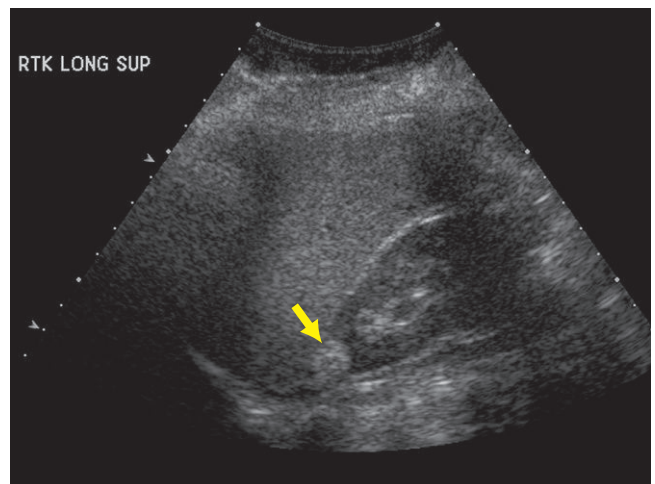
Real-time ultrasound examination of the right kidney demonstrates a well-demarcated echogenic mass (arrow) in the upper pole of the right kidney.
